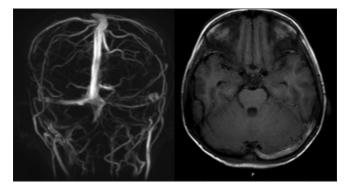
First magnetic resonance imaging brain showing thrombosis of the left transverse and sigmoid sinus, visualized part of the left internal jugular vein, and partial thrombosis of the right transverse sinus
